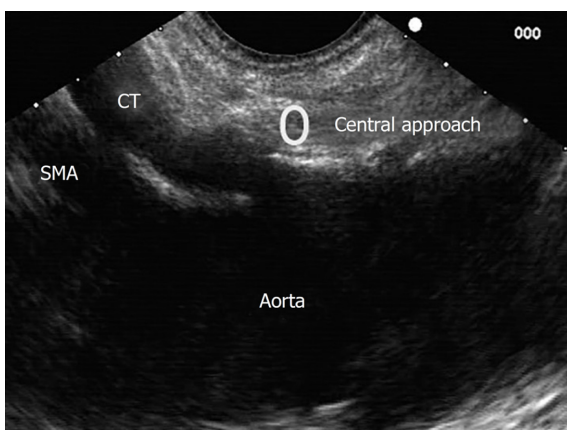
Central approach for endosonography-guided celiac plexus neurolysis. SMA: Superior mesenteric artery; CT: Celiac trunk.
